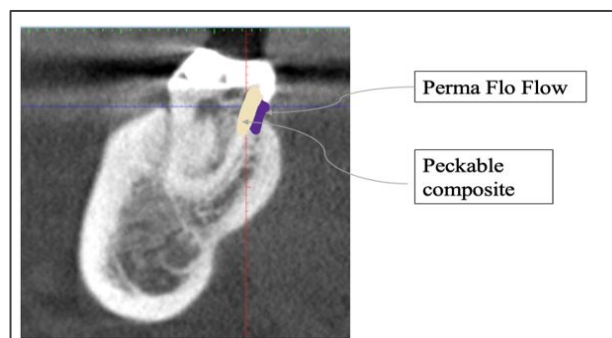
The preoperative CBCT image was used to present the lingual sealing of the cervical resorptive defect in tooth #47.
